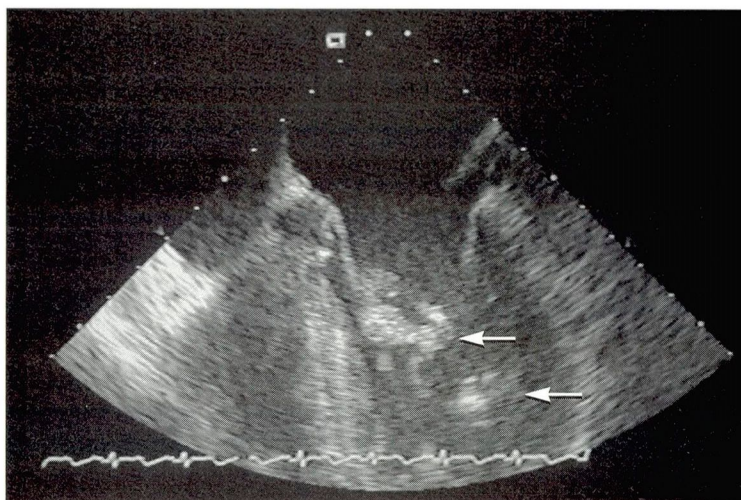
Transesophageal echocardiogram showing vegetations on anterior leaflet (top arrow) and papillary muscle (bottom arrow) of mitral valve.
